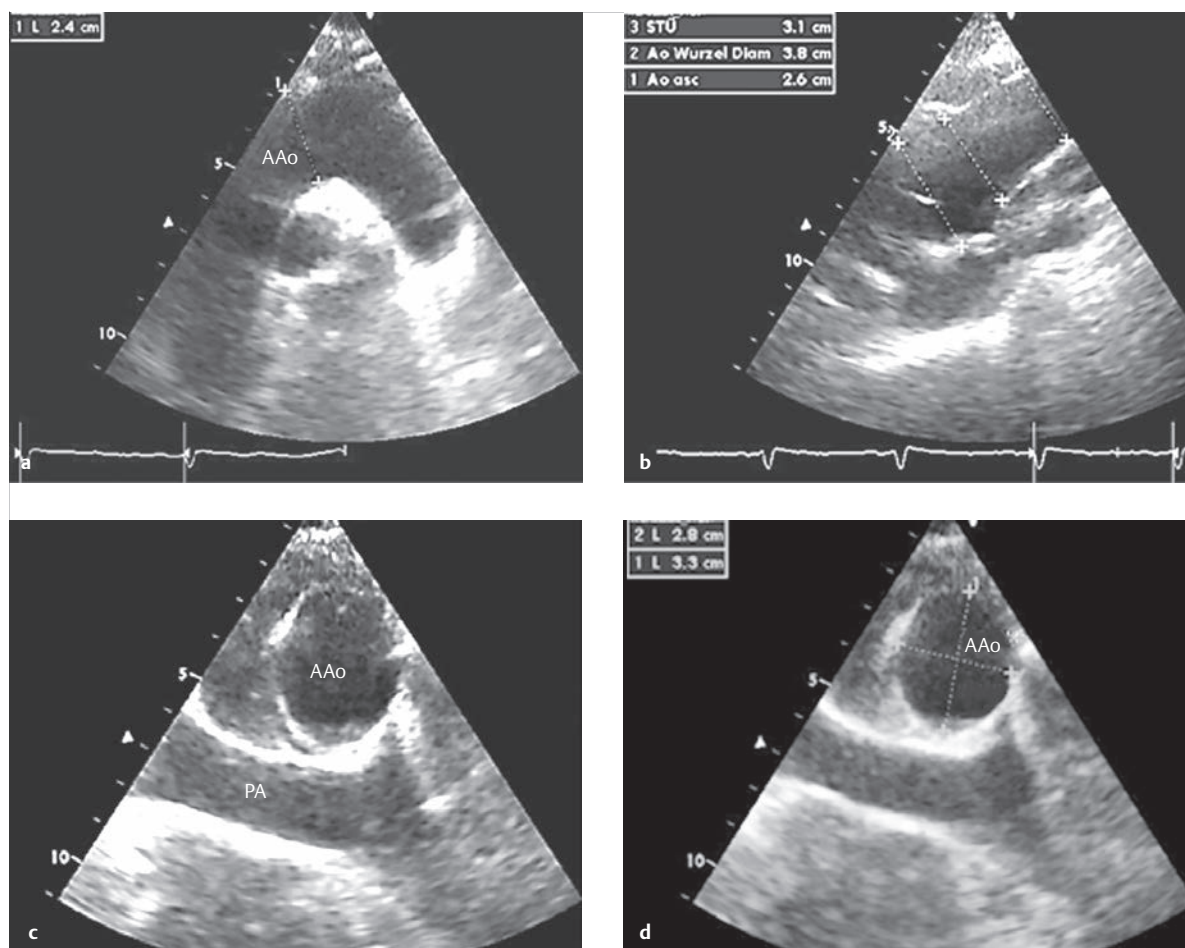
Dilated aortic root in a case of Marfan syndrome. Thirty-two-year-old female patient with Marfan syndrome and a family history (father died from aortic rupture due to acute type A dissection). The aortic root is enlarged to a maximum of 3.8 cm (b). Color Doppler depicts moderate mitral valve insufficiency (e). The topogram (g) of the corresponding MDCT depicts the osteosynthesis material near the spinal column, condition after scoliosis surgery and pectus excavatum. The aortic root, dilated to a maximum of 4 cm, is depicted in h–j. The MDCT pulmonary window (k) depicts clear pectus excavatum with ventricular narrowing. MRI flow measurements revealed a minor regurgitation fraction of 5% (l, light blue area), only.
